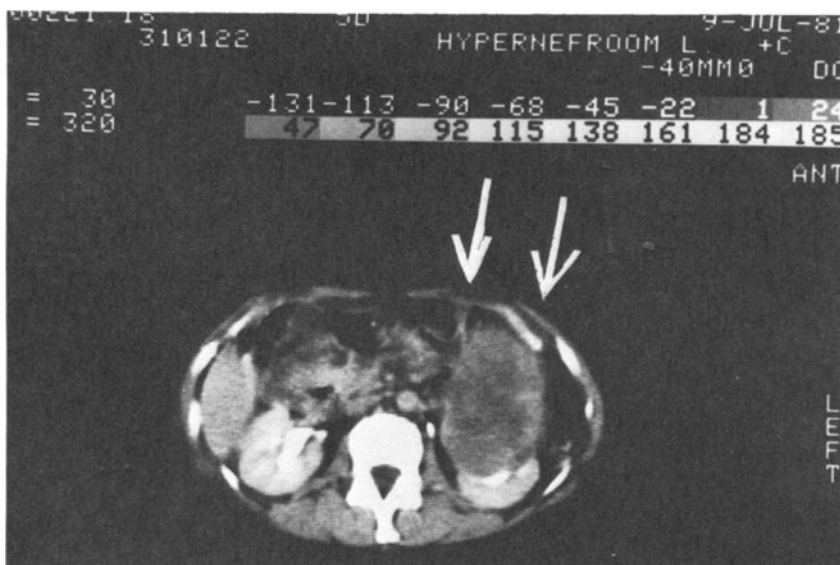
Renal tumor is suggested by the irregular form and intermediate density on CT scan.
